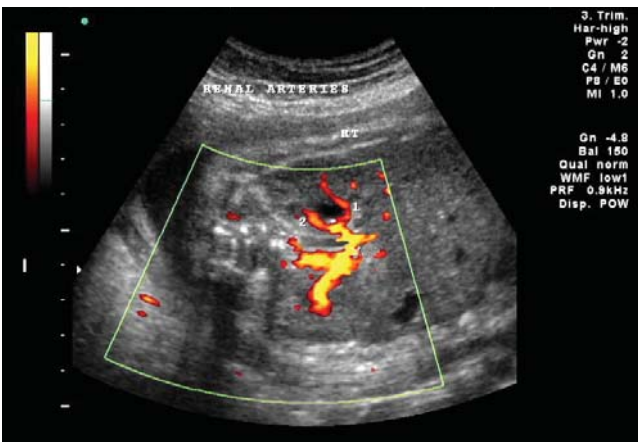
Colour flow and spectral Doppler demonstrated two main renal arteries
